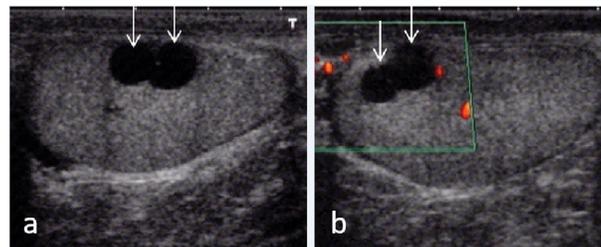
Ultrasound images of two superimposed simple testicular cysts (arrow). (a) Transverse projection. (b) Transverse projection with power Doppler imaging; the cysts are avascular.
